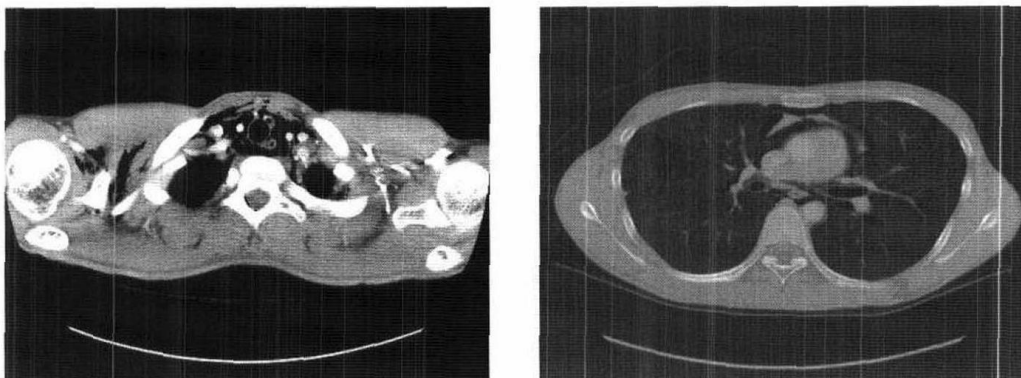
Chest CT showed pneumomediastinum and pneumopericardium.
